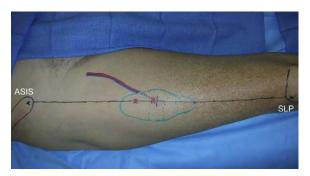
Skin markings for the harvesting of the ALT flap. A line is drawn from the anterior superior iliac spine (ASIS) to the superior lateral patella (SLP). The halfway point between this line is marked, and Doppler ultrasonography is used to identify the perforators. Once the perforators are marked (*red x's*), the flap to be harvested is marked (*green line*).
